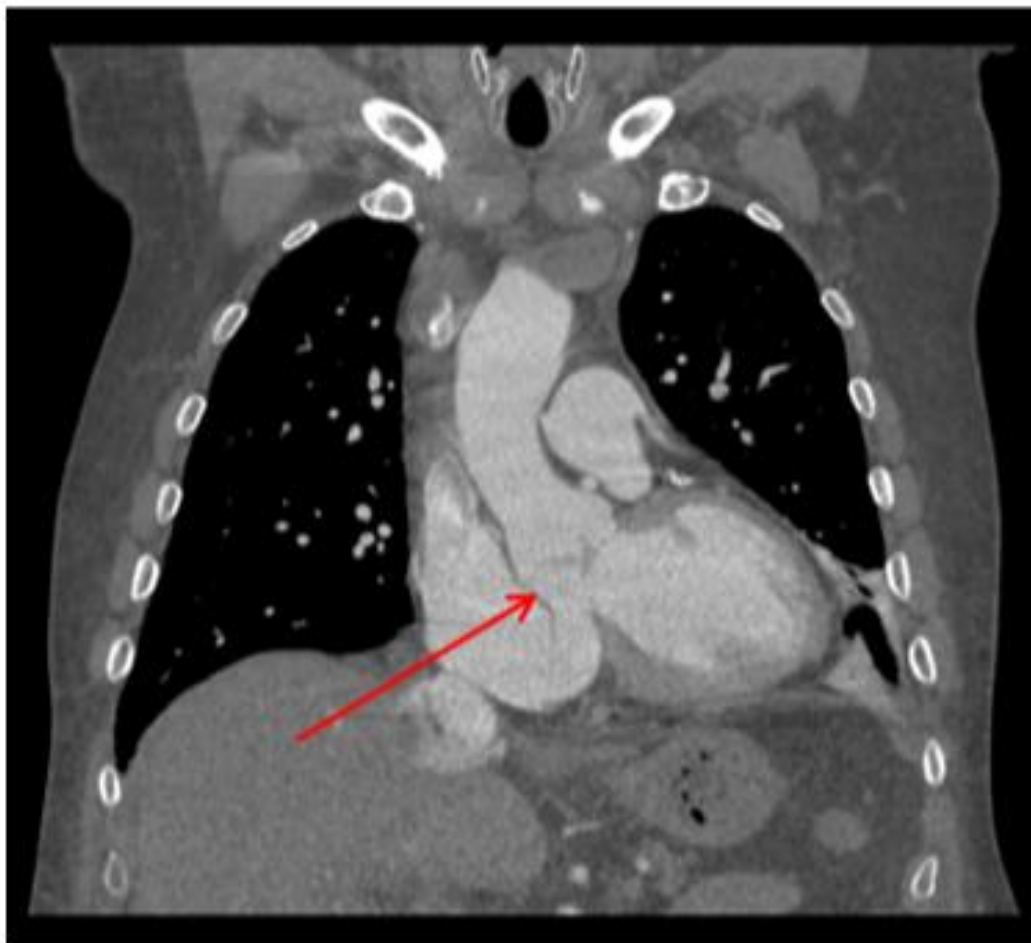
Contrast-enhanced computed tomography scan performed before surgery. The arrow indicates the site of the aneurysm rupture into the right atrium.
